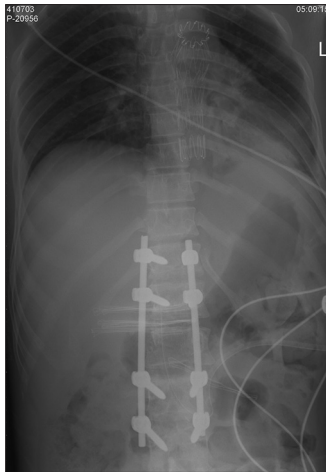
Posttreatment radiograph showing spinal fixation prosthesis with pedicle screws. Note also the stent graft in proximal descending aorta
